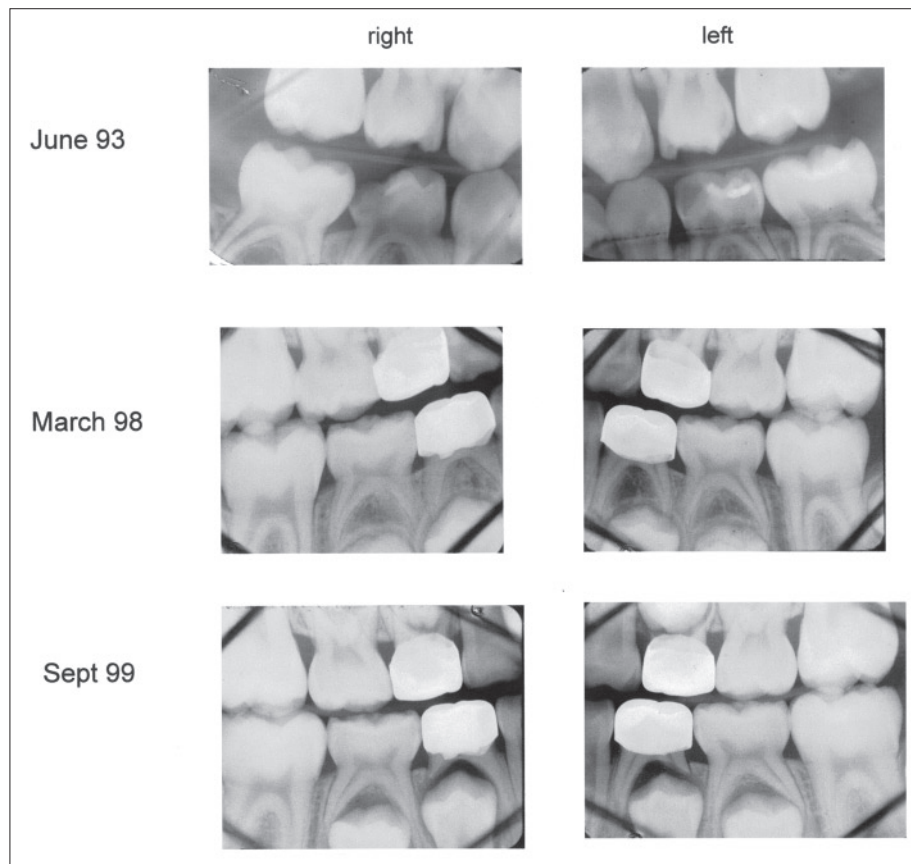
This is an example of treating bilaterally similar deep caries approaching the pulp in 2 different ways. The right molar received a formocresol pulpotomy while the left received an indirect pulp therapy after 1 month of glass ionomer caries lesion control. Postoperative radiographs at 5 and 6 years later show good success in both molars with normal exfoliation.
